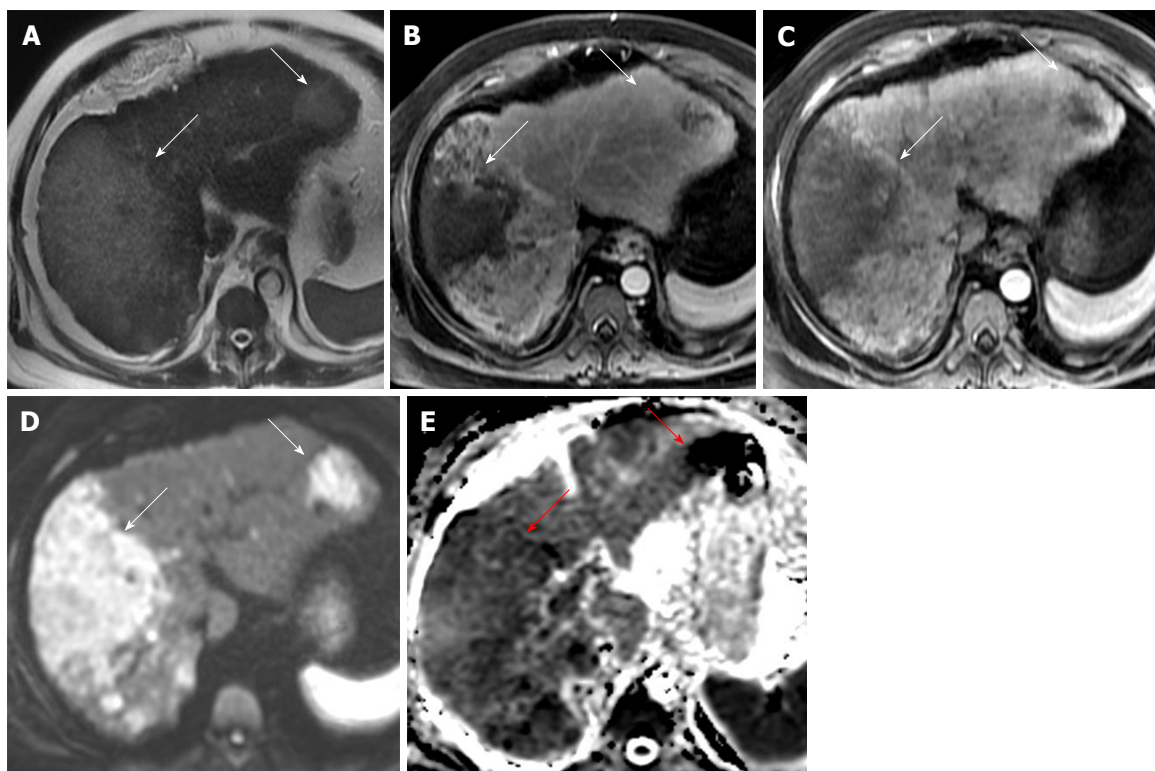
A 66-year-old lady with multifocal infiltrative hepatocellular carcinoma with improved detection on diffusion-weighted imaging. (A) Axial T2 weighted image demonstrates multifocal areas of T2 hyperintense masses (white arrows) which demonstrate heterogeneous arterial hyperenhancement on post gadolinium late arterial phase images (B) and washout appearance on portal venous phase images (C). (D) Axial DWI image at b-600 and (E) ADC image show that these masses demonstrate restricted diffusion and are better appreciated than the dynamic phase images. Serum Alpha fetoprotein value of 1552. DWI: Diffusion-weighted imaging.
